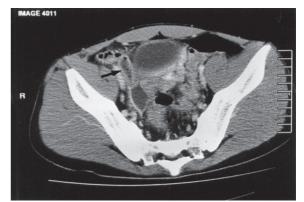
CT scan of the pelvis showing fluid tracking down the right patent processus vaginalis (arrow).
